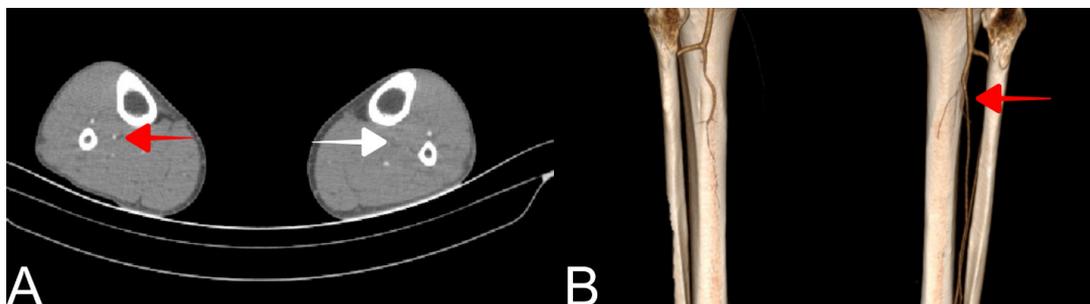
Left posterior tibial artery (PTA) thrombosis confirmed by computed tomography (CT) angiography and three-dimensional volume rendering images: (A) Shows the hypodense filling defect in the left PTA (white arrow), and the right PTA which appeared normal (red arrow); and (B) Similarly, three-dimensional volume-rendering CT images show that the right PTA is normal (red arrow) while the left PTA cannot be seen.
